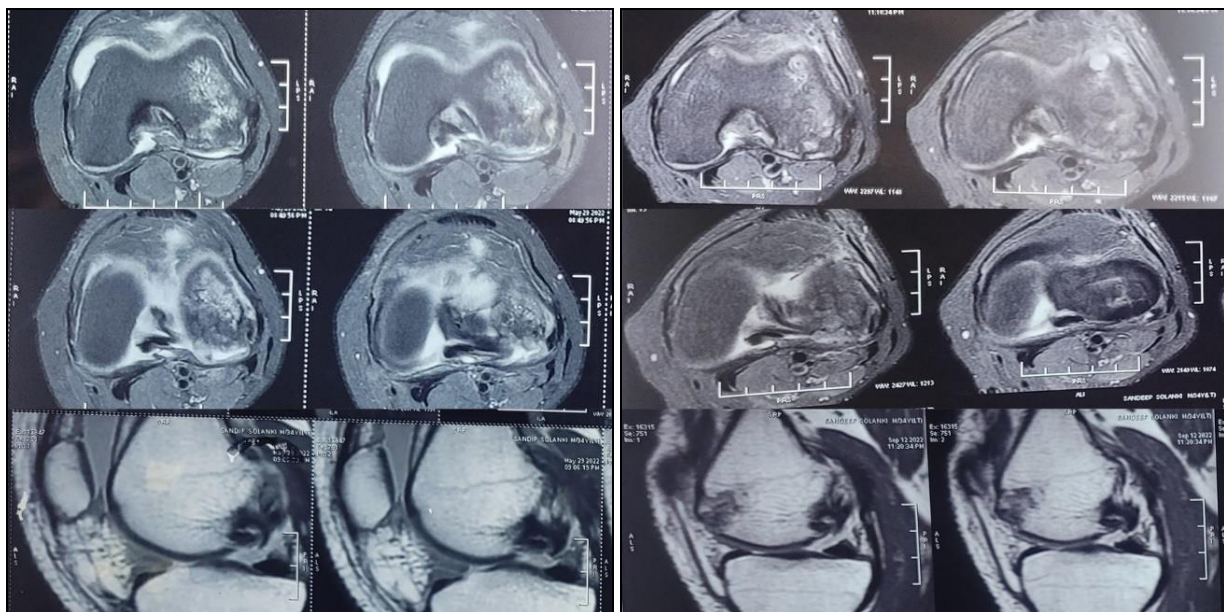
a, b: Image on the left (2a) transverse MRI section (preop) shows subchondral oedema and necrosis of the lateral femoral condyle. Image on the right (2b) shows postoperative uptake of recipient plugs and lower sagittal section section shows non weight bearing donor area.
